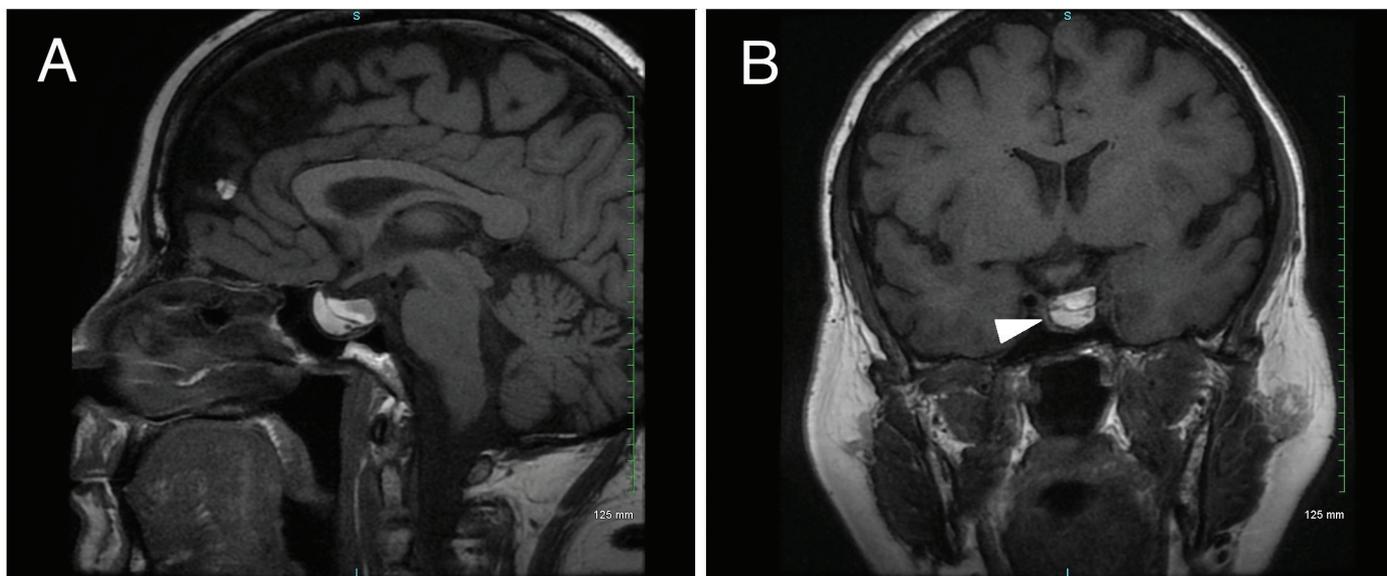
MRI of sella turcica in sagittal (A) and coronary (B) views showing hyperintense T1 signal present in the pituitary gland, which measures 1.2 × 1.5 × 2 cm. A thin rim of normal pituitary tissue is seen in the right side of the hemorrhagic component (white arrow). There is mild deviation of the pituitary stalk to the right, and no compression of the optic nerves or optic chiasm.
